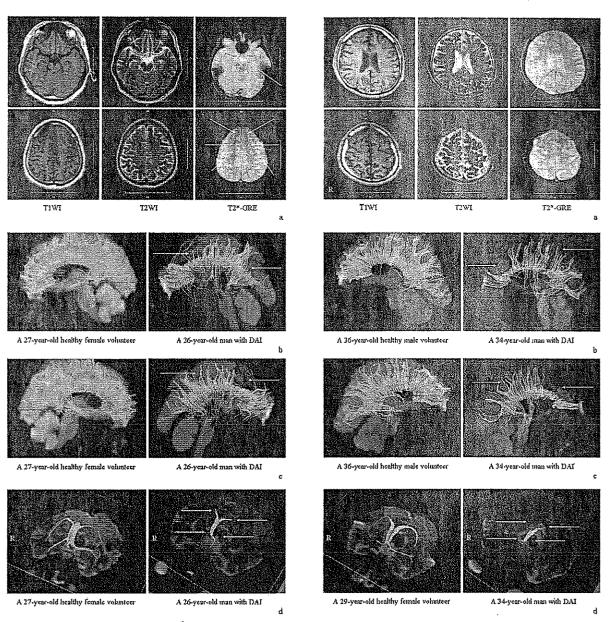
The MRI of a 26-year-old man with DAI. (a) No abnormal lesions were found on the T1-weighted (T1WI) and the T2-weighted (T2WI) MR images. Multiple small foci showing signal hypo-intensity were detected in the left hippocampus and the frontal lobes bilaterally on the T2*-weighted gradient-echo MR images (T2*-GRE) (arrows). (b) DTI fiber tractography from the seed area around the corpus callosum on the left side midsagittal image. There were fewer fibers extending to the frontal, parietal, and occipital white matter and they were even absent in some areas (arrows), in comparison with the normal volunteer image. (c) DTI fiber tractography from the seed area around the corpus callosum on the right side midsagittal image. There were fewer fibers extending to the frontal, parietal, and occipital white matter and they were even absent in some areas (arrows), in comparison with the normal volunteer image. (d) DTI fiber tractography from the seed area around the fornix. The fornix fibers were interrupted (arrows), in comparison with the normal volunteer image.
